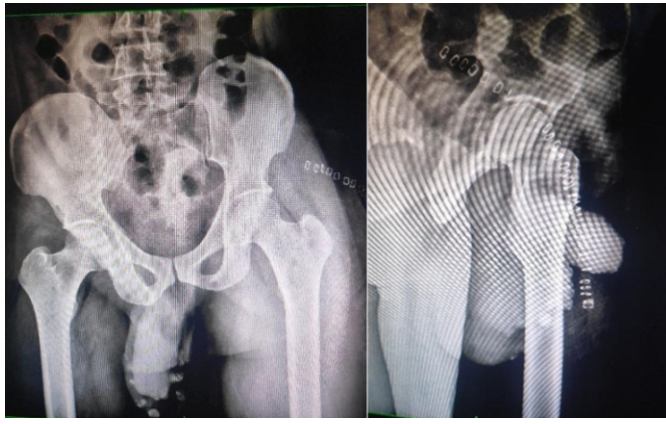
Post-operative X-rays.
